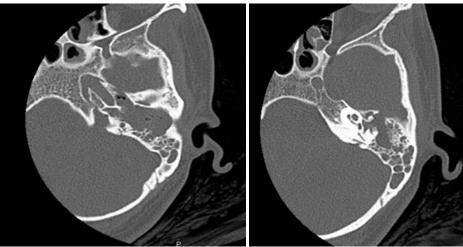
Petrous Axial Computed Tomography without contrast
